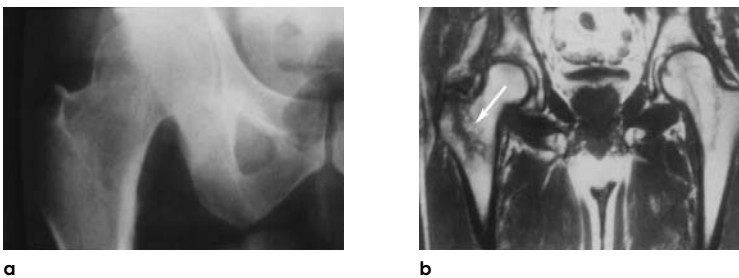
Undisplaced fracture documented by MRI.
